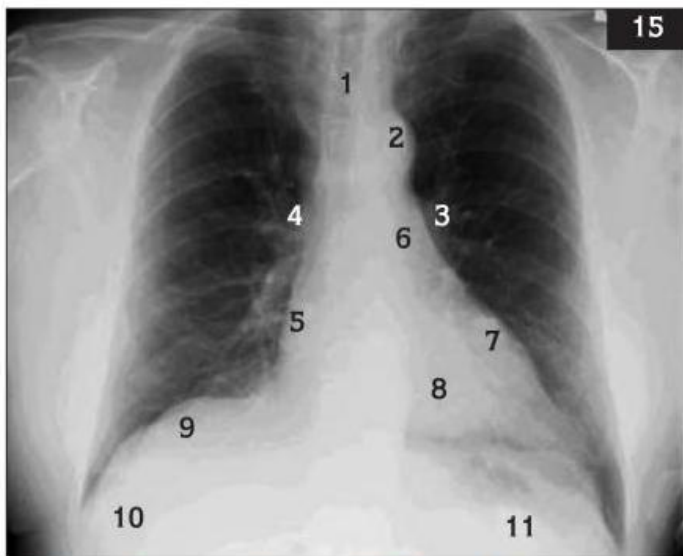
shows a normal PA radiograph with labelling of the important structures. The mediastinal structures are superimposed on each other and are seen together as a unit. Further definition of the mediastinum can be seen on a CT scan and will be discussed later.
